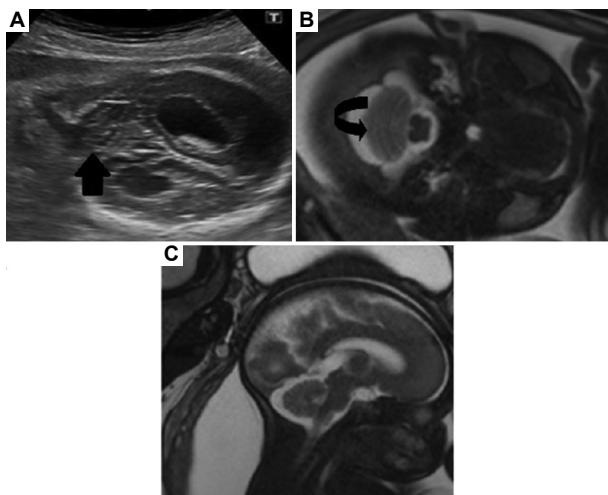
Imaging of rhombencephalosynapsis. (A) Coronal ultrasound image of a 30-week fetus demonstrates fusion of the cerebellar hemispheres (black arrow). Similar to MRI, the transverse folding of the fused cerebellum is a distinctive feature. (B) Axial TRUFI image demonstrates fused cerebellar hemispheres and continuous cerebellar folia (curved black arrow). (C) Sagittal TRUFI image shows midline sections revealing the absence of the vermis. Abbreviations: MRI: Magnetic resonance imaging; TRUFI: True fast imaging with steady-state free precession.
